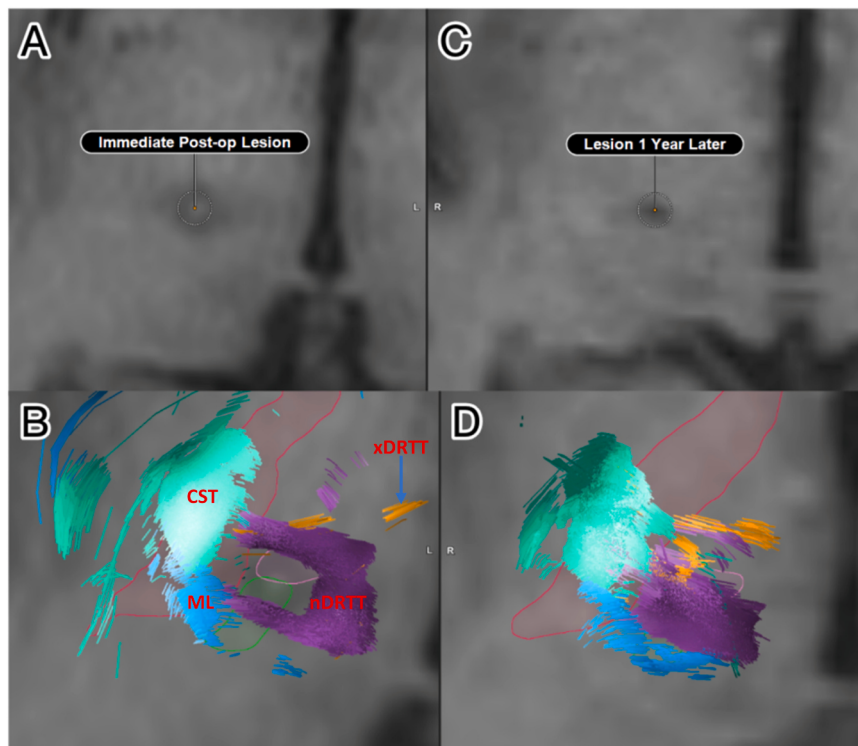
Axial T1-weighted images of lesion sites in a 66-year-old right-handed female with ET. (A) Immediately post-op lesion core with surrounding edema. (B) FT2 tractography overlay with superimposed stereotactic atlas immediately post-op. The nDRTT (purple), xDRTT (orange), medial lemniscus (blue), and corticospinal tract (green) are shown. Atlas registration shows the internal capsule (red outline), VPL (green outline), and VIM (pink outline). (C) Ablation site 1-year post-op. Lesion core is no longer observed, showing a decrease in size. (D) FT2 tractography overlay with superimposed stereotactic atlas 1-year post-op. The nDRTT (purple), xDRTT (orange), medial lemniscus (blue), and corticospinal tract (green) are shown. Atlas registration shows the internal capsule (red outline) and VIM (pink outline). Abbreviations for key structures are displayed on the images in bold red text for clarity.
